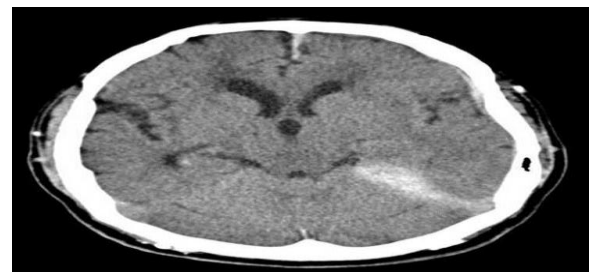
An axial CT scan of the brain shows the hyper-density going up with the dural mater.
